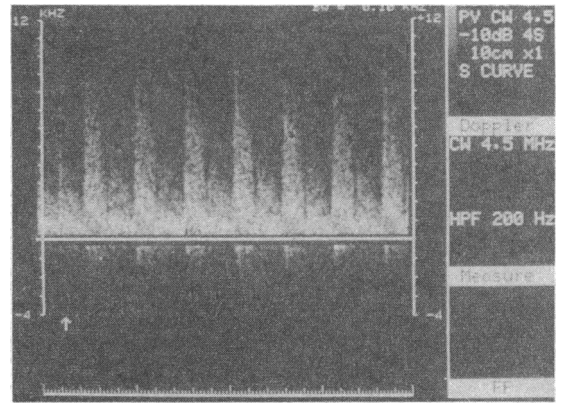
Doppler signal in 35 year old woman with amaurosis fugax showing a very high peak systolic frequency from symptomatic internal carotid artery consistent with severe stenosis. The atheroma was echolucent and no abnormality was seen on B mode imaging, but angiography confirmed a tight stenosis
